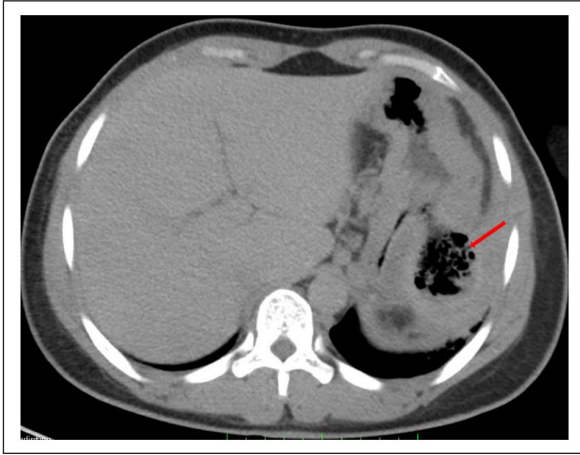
Computed tomography axial section image shows an intraluminal gastric formation; well-limited oval, heterogeneously dense, and containing air bubbles, not enhanced after contrast injection.
